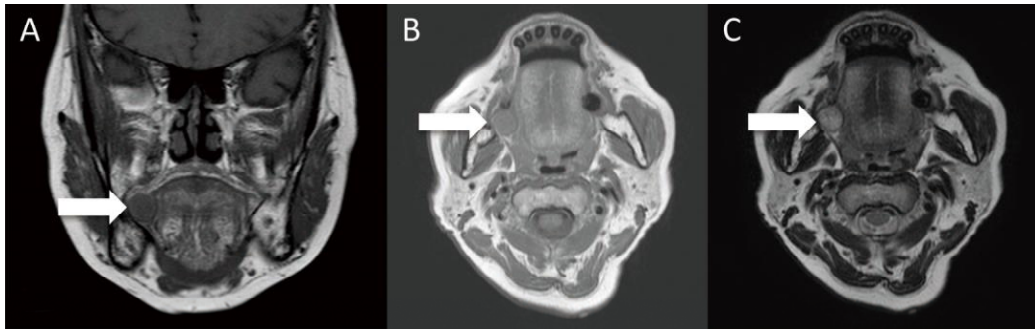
MRI showing a well-defined, smooth, capsular outlined lesion in the right retromolar region. A (coronal plane) and B (transverse plane) show T1-weighted MRI with low signals. C (transverse plane) shows T2-weighted MRI with high signals.
